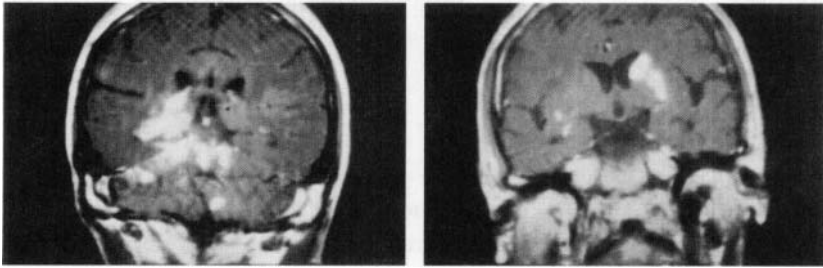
Coccidioidomycosis granulomas. Postcontrast T1-weighted coronal images at the level of ventricles show enhancing lesions in the right periventricular region. This was subsequently confirmed as coccidioidomycosis. (Courtesy Drs. Suresh Mukherji and M. Castillo, North Carolina.)
